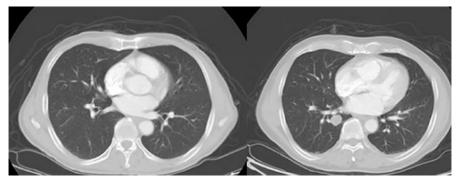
CT on 7/3/2013 and 2/4/2015
